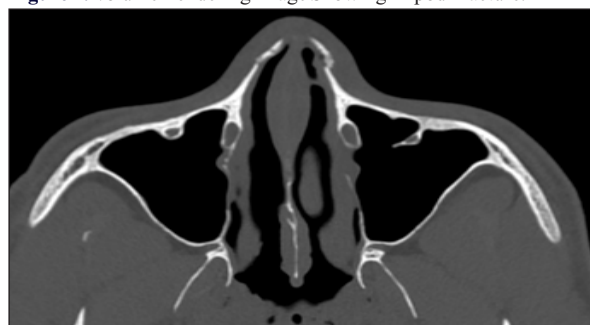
Axial CT Image Showing Fracture Of Bilateral Nasal Bones.
